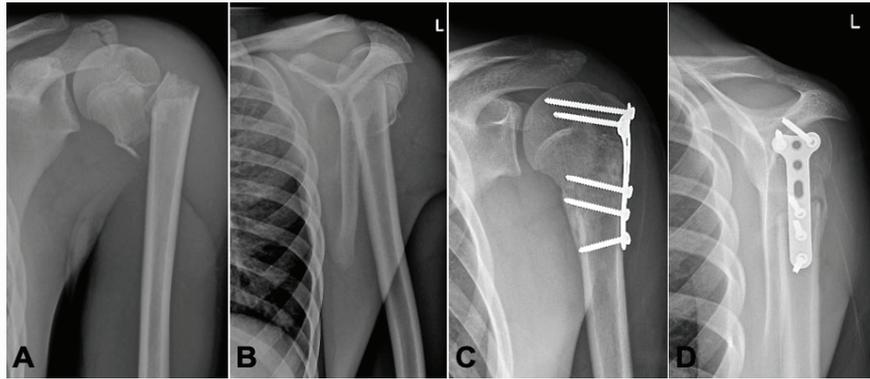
Radiographic Shoulder views, (Patient No. 4) (ap/Neer). A/B dorsally displaced humeral head. C/D 6 weeks after open reduction and plate fixation.
